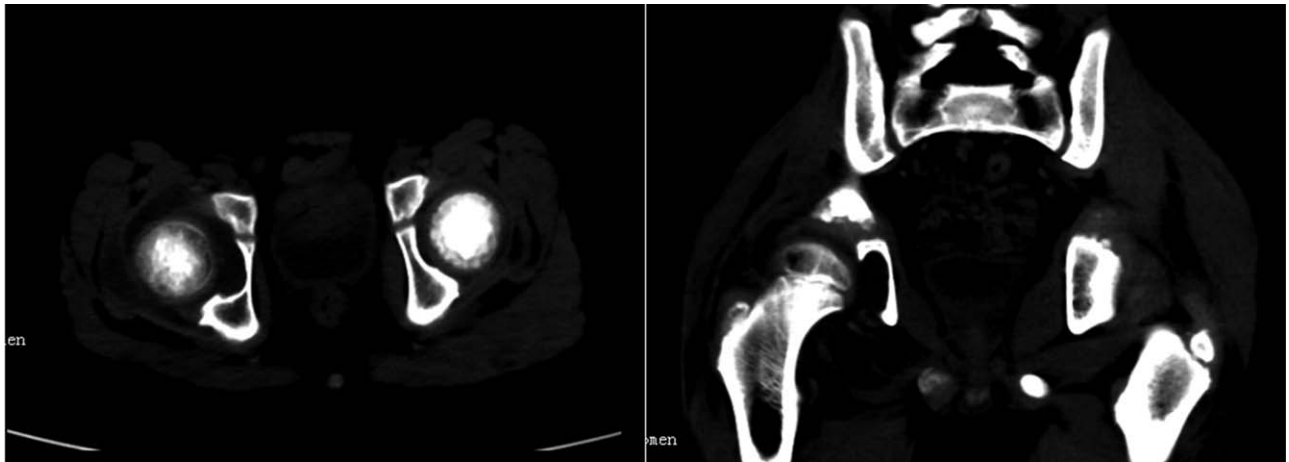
CT showed destruction of the right hip-joint bone. CT = computed tomography.
